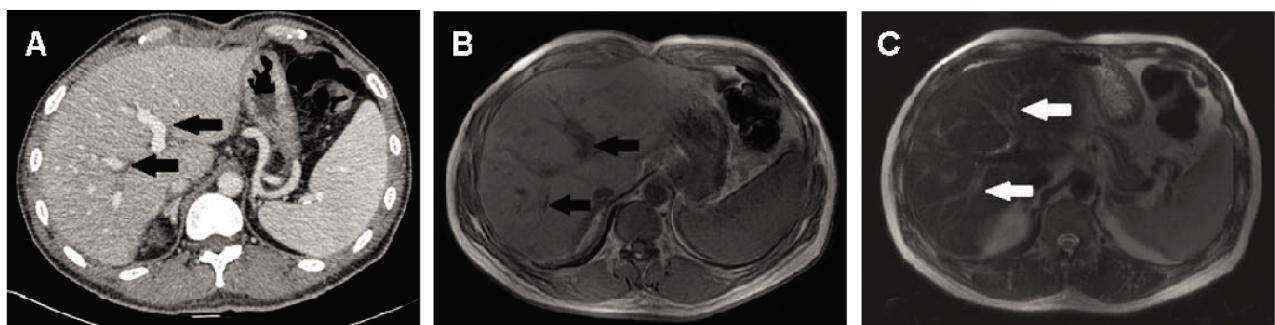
男性,58岁,术后并发移植肝排斥。术后 CT 出现肝静脉大分支周围 PVLs(黑色箭号,A);术后第 128 天随访 MRI(B,C)示:T1WI 上门静脉大分支两侧轨道样稍低异常信号(黑色箭号,B);T2WI 上显示为门静脉大分支两侧轨道样稍高异常信号(白色箭号,C)。
